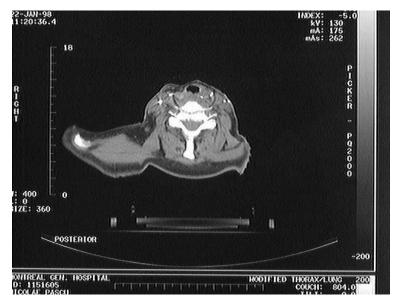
A CT image through a patient's neck. The target volume has been marked on the film by the physician.
